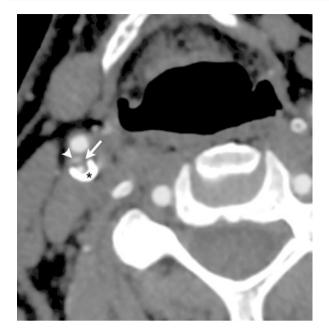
CTA image showing a complex plaque at the right internal carotid artery bulb, with an ulceration (*arrowhead*), lipid-rich necrotic plaque (*arrow*), and calcified plaque (*star*)
